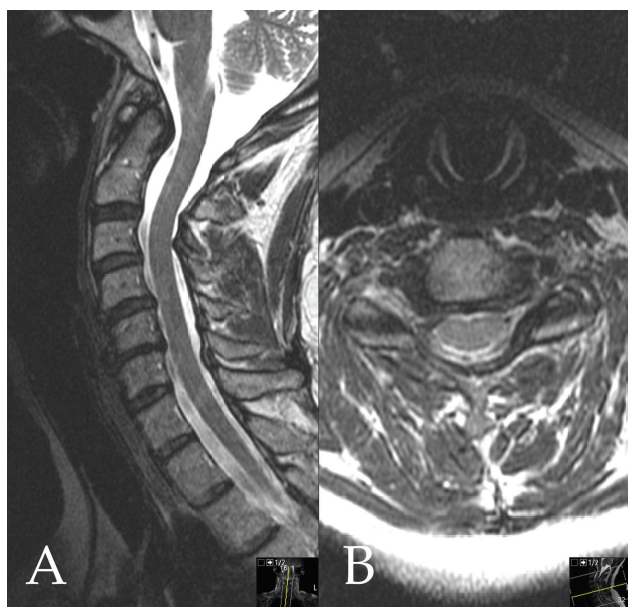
(A) Sagittal and (B) axial magnetic resonance imaging of patient 1 showing disc height loss at C5-6 resulting in right greater than left foraminal stenosis.
